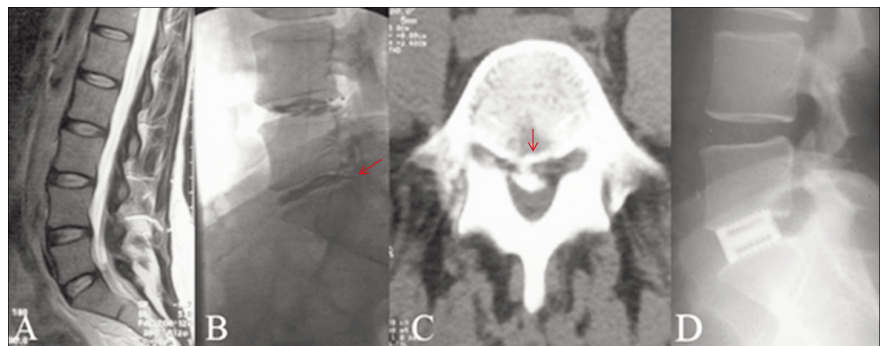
A) Sagittal T2-weighted magnetic resonance imaging showing mild loss of lordosis; B) discography showing an annulus fibrosus tear in the L5-S1 disc (note the contrast medium in the spinal canal); C) computed tomography discography showing contrast material in spinal canal (note the central location of the annulus fibrosus tear); D) a postoperative lateral lumbar radiograph of the patient.
